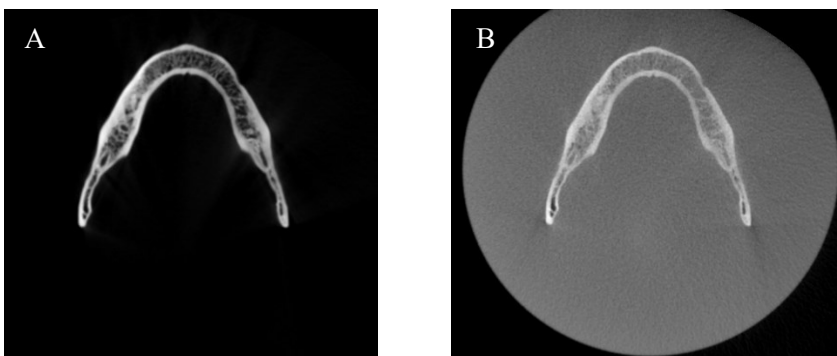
Axials views of reconstructed CBCT images (A – mandible scanned without water, B – immersed into distilled water)
